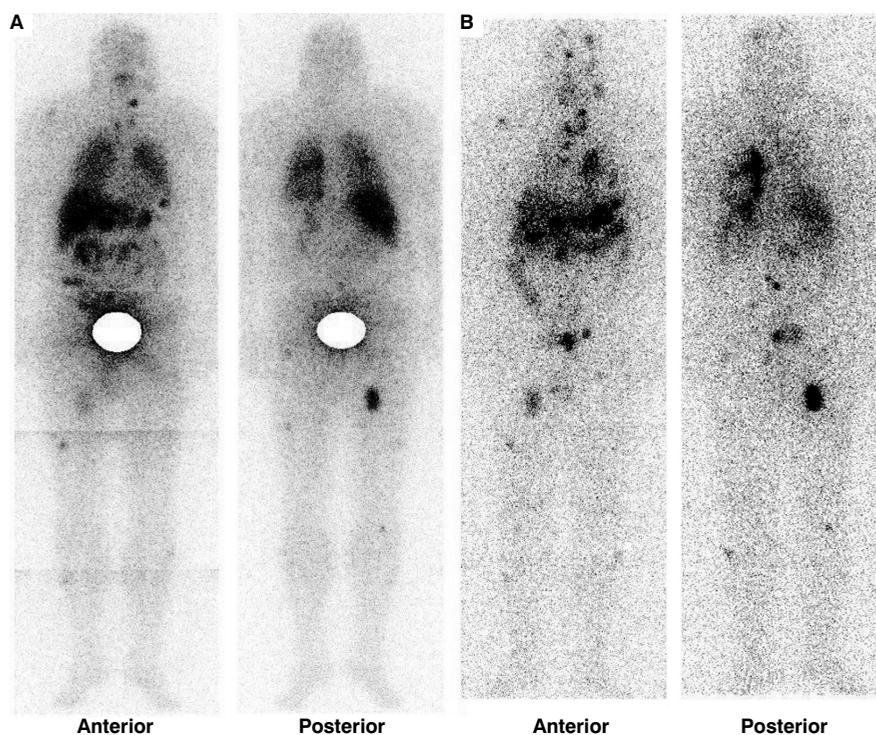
Whole body scintigram of patient with spread of metastatic melanoma. A. 4 hours after radiopharmaceutical injection; B. 24 hours after radiopharmaceutical injection; radioactivity in urinary bladder on the 4 h image has been masked; there are seen numerous melanoma metastases to soft tissue of the extremities and to many internal organs, including brain, lungs, and liver, particularly clearly visible on the image recorded 24 hours after radiopharmaceutical injection.
